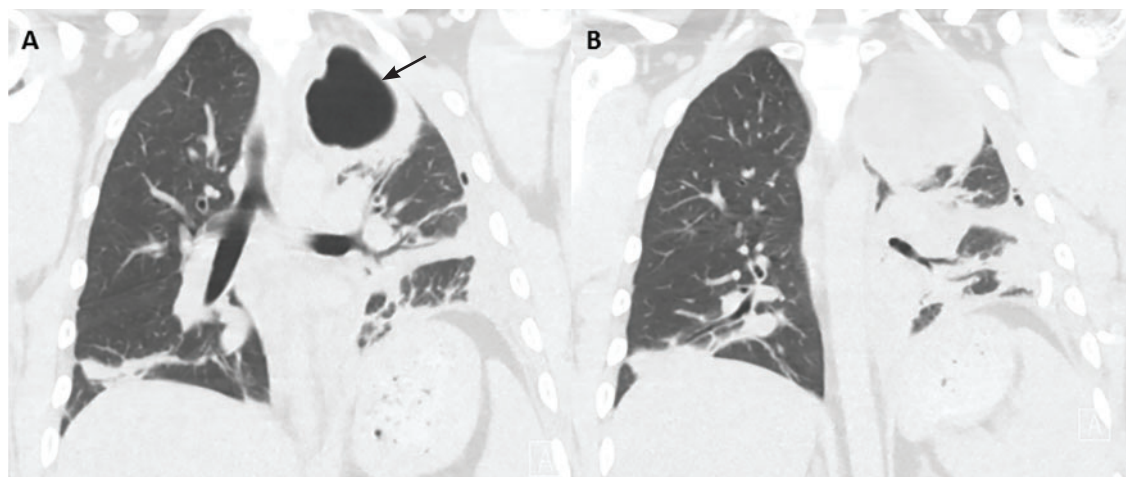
Computed tomography 2 days after initial chest tube placement showed a non-communicating apical pocket.
